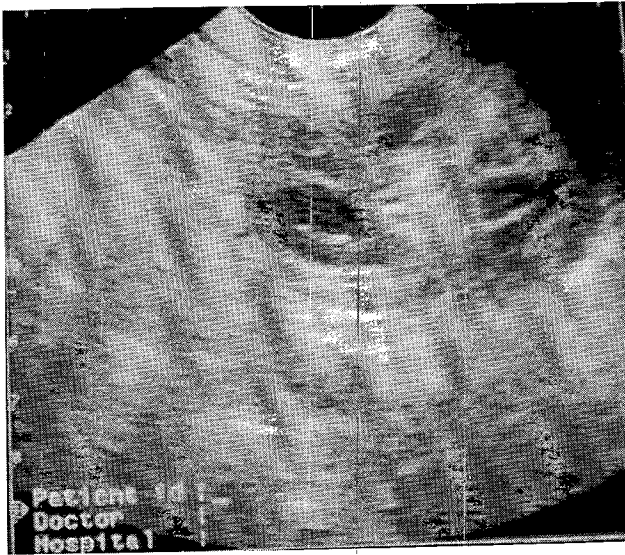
A normal echogenic knot (C-shaped) with a central anechoic area in ultrasonography.
